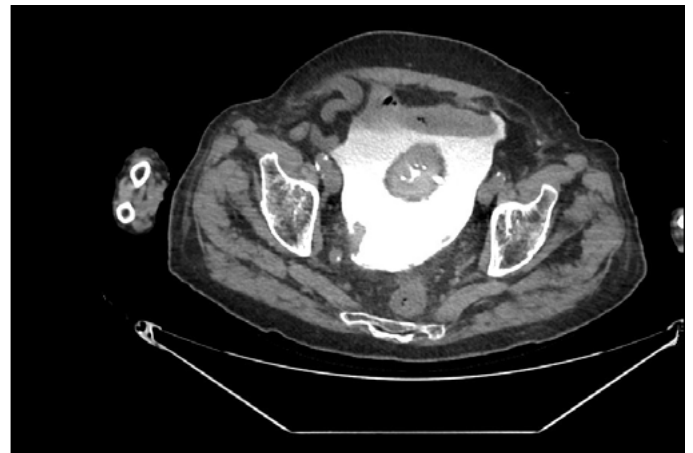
CT abdomen and pelvis, with contrast in the excretory phase, showing contrast leakage secondary to bladder perforation.
